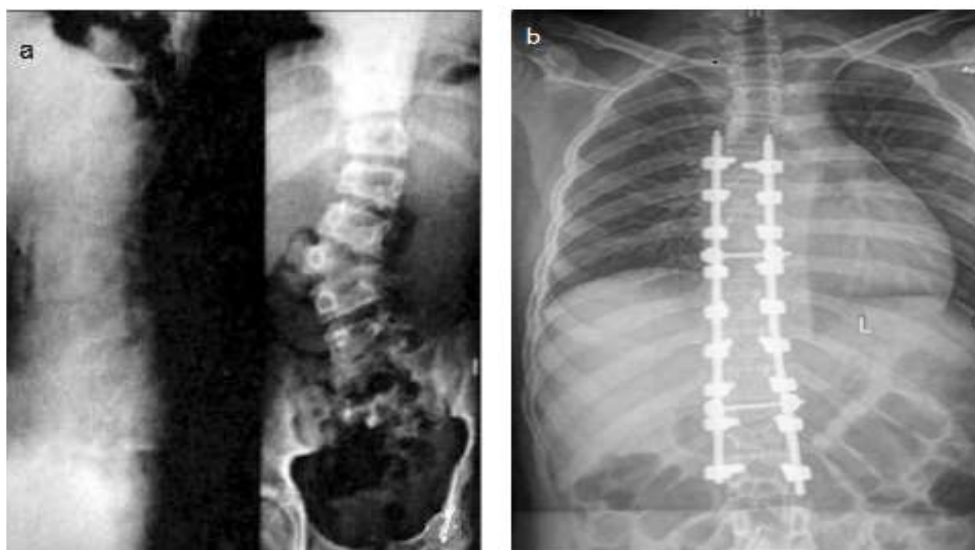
Anteroposterior and lateral X-rays of one case before and after surgery. a) anteroposterior and lateral X-ray before surgery; b) anteroposterior and lateral X-rays one year after surgery.
